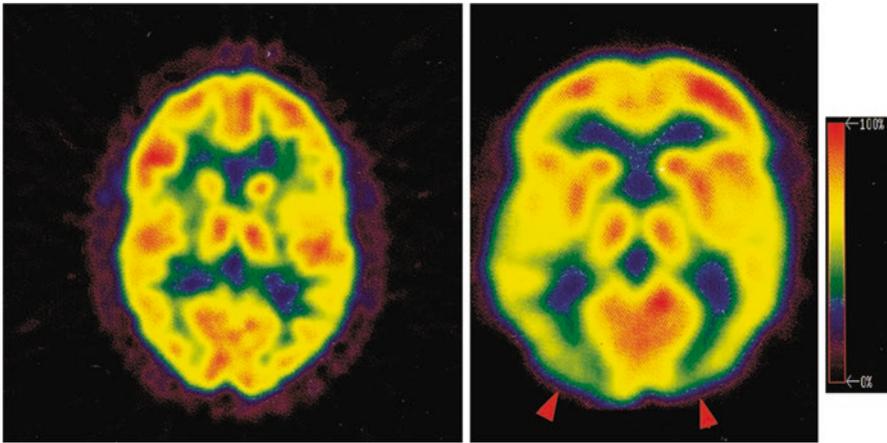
FDG-PET; representative transaxial slice in height of basal ganglia, *left*: normal control subject, *right*: whiplash patient; *arrows* indicate hypometabolism in the posterior parietal occipital region (data from Otte et al. (1997b), adapted from Otte et al. (eds) (2004) Nuclear Medicine in Psychiatry, Springer, Heidelberg)
